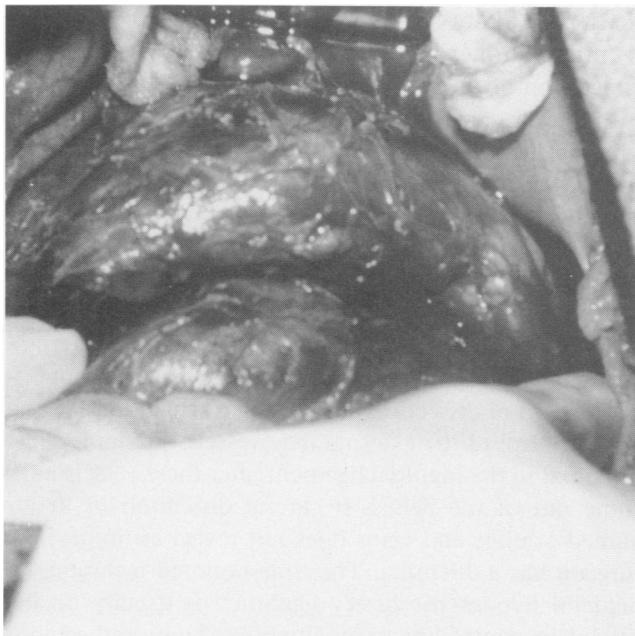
Peripancreatic hematoma after blunt trauma (From Feliciano DV. In Schwartz SI, Ellis H, eds. *Maingot's Abdominal Operations*, ninth edition. East Norwalk, CT: Appleton & Lange, 1989; publication pending. Reprinted with permission.)
